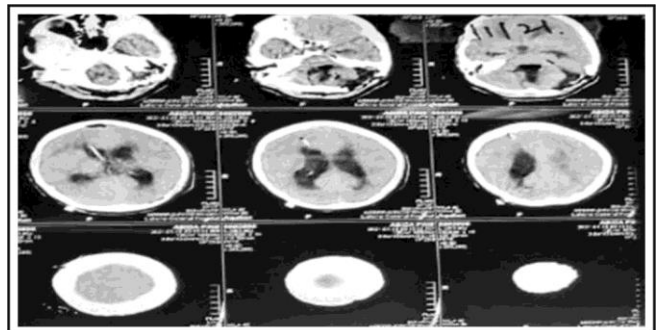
CT Scan Brain Plain – Left Cerebellar Tumor and Hydrocephalus. (Scans used with patient's permission)
